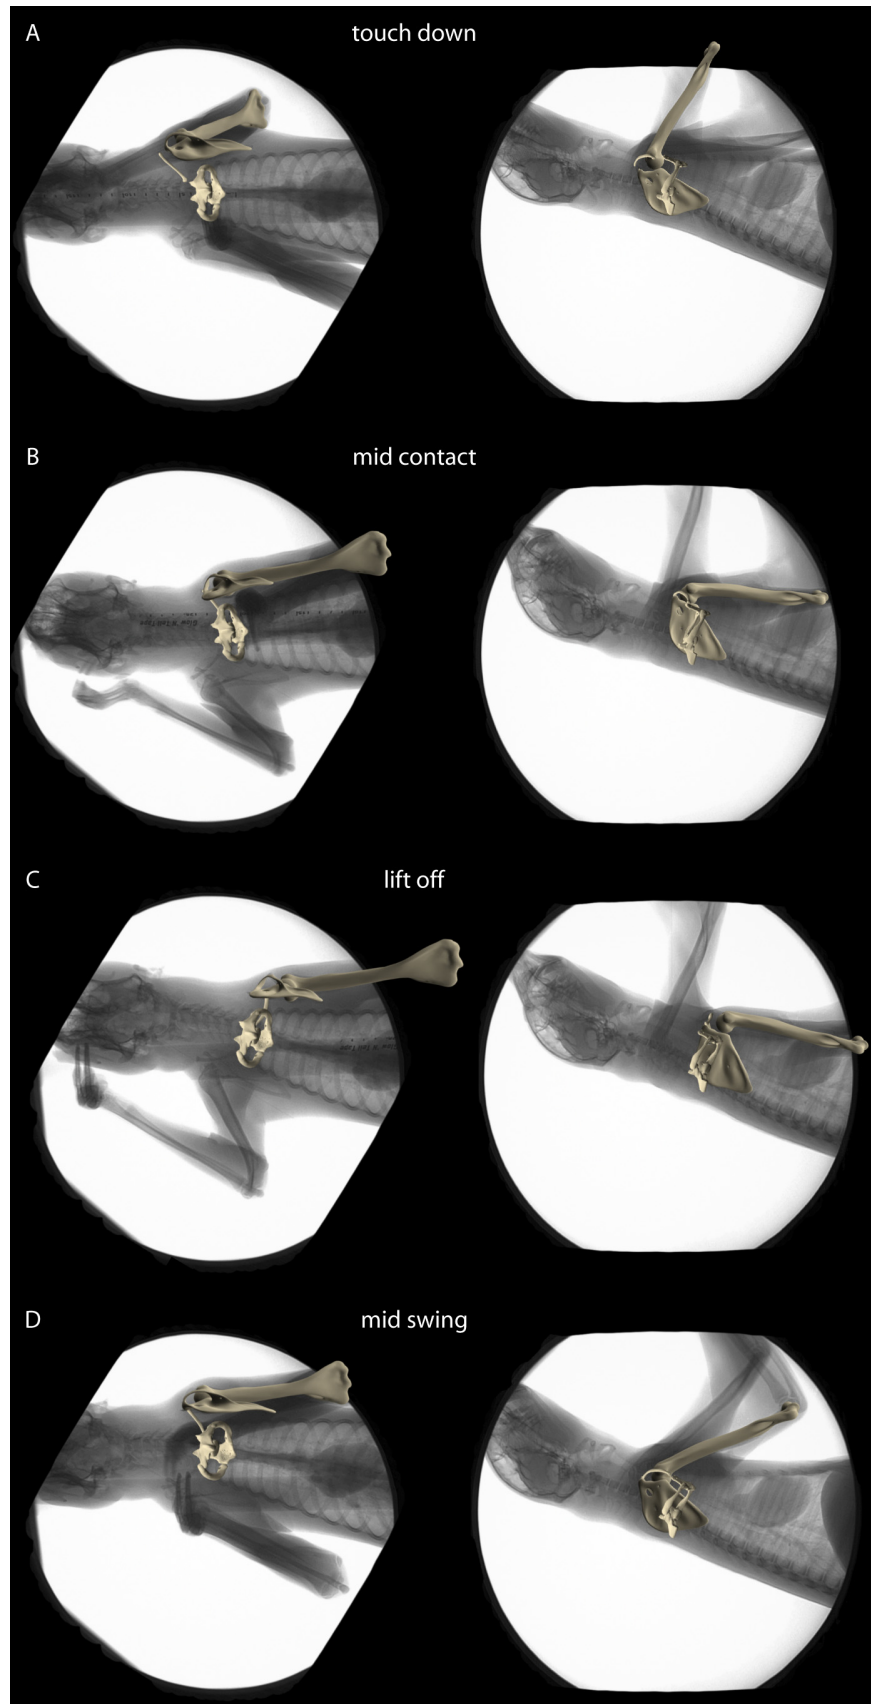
Representative frames of instants of (A) touch down, (B) mid contact, (C) lift off, and (D) mid swing. X-ray image with bone model posed to match the x-ray shadow is shown for the dorso-ventral projection and the latero-lateral projection.
